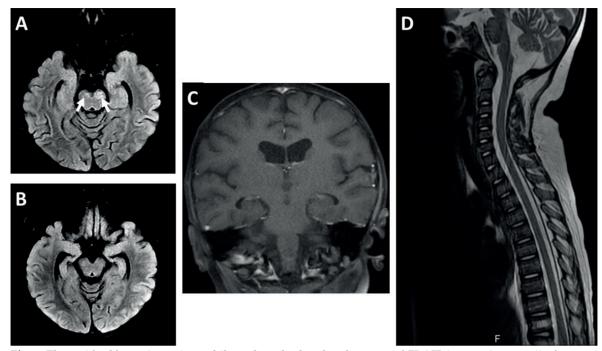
The residual hyperintensity on bilateral cerebral peduncles on axial FLAIR images (*arrows*, *A*) after one-month, is completely resolved on six-month follow-up (*B*). Neither contrast enhancement on brain stem on coronal T1-weighted spin-echo image (*C*) nor residual spinal cord lesions on sagittal T2-weighted image (*D*) is seen on one-month follow-up brain and cervicothoracic spinal MRI.
